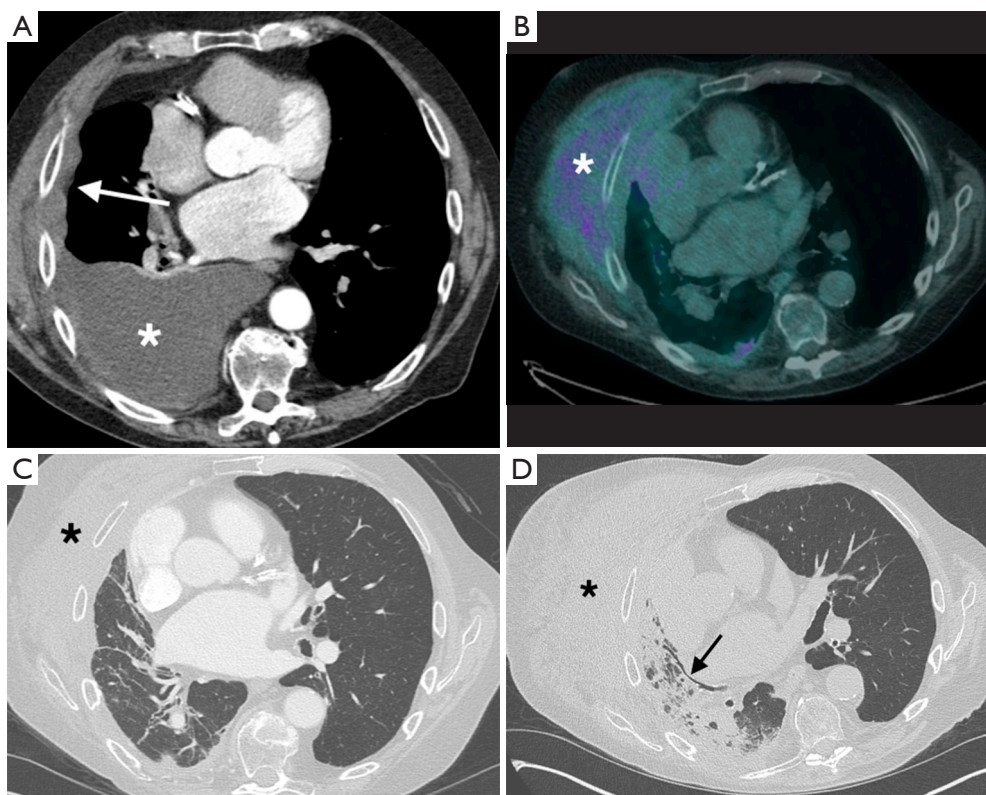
A 77-year-old man with right epithelioid mesothelioma underwent EP/D. Pre-operative CT thorax with IV contrast (A) demonstrates a large right pleural effusion with nodular pleural thickening in the right hemithorax (arrow). Follow-up ^{18}F -FDG PET/CT 1-year post right EP/D (B) demonstrates a large FDG-avid soft tissue mass in the right anterolateral chest wall (star) consistent with local tumor recurrence. This was subsequently treated with radiotherapy. CT thorax during the radiation treatment (C) shows reduction in size of the chest wall mass (star) with linear atelectasis in the right lung. 3 months after completion of radiation treatment, the patient developed progressive dyspnea and underwent a CT thorax (D), which demonstrates new consolidative and ground glass opacities in the right lung in a predominantly peribronchial distribution with bronchial dilatation (arrow). These imaging appearances are consistent with radiation pneumonitis. EP/D, extended pleurectomy/decortication; ^{18}F -FDG PET/CT, ^{18}F -fluorodeoxyglucose positron emission tomography/Computed tomography; FDG, fluorodeoxyglucose.
